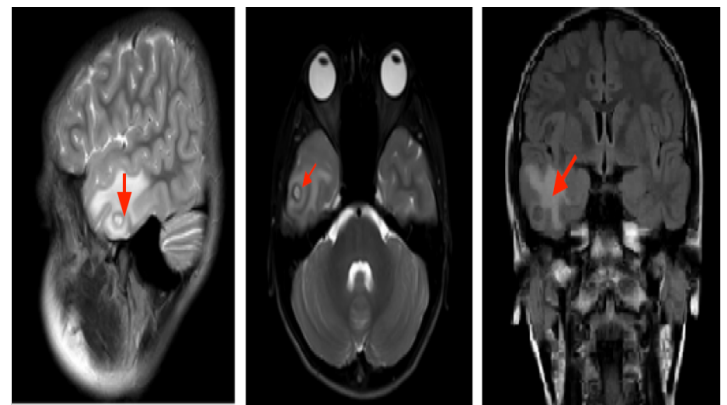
Contrast-enhanced MRI showing a small right temporal ring-enhancing lesion with marked surrounding vasogenic edema
